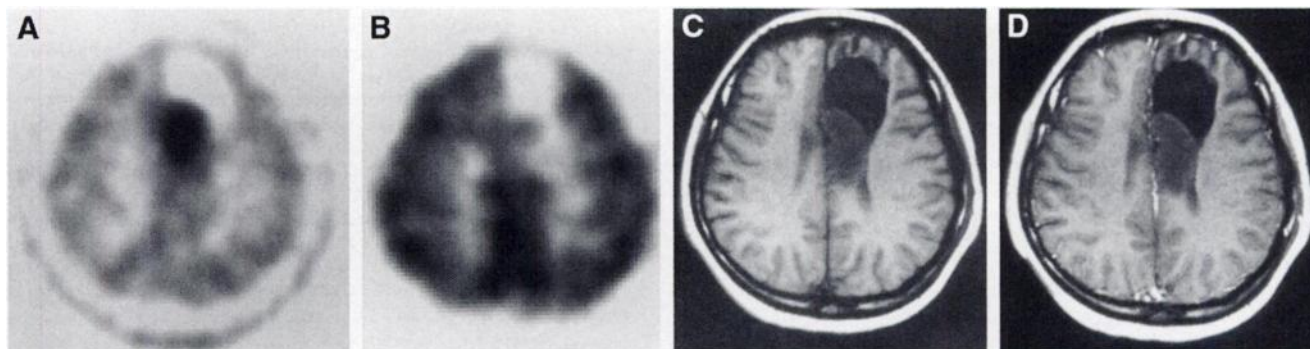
32-y-old woman with recurrent astrocytic tumor grade II (patient 6). (A) FMT PET image obtained at 30 min postinjection demonstrates higher tumor uptake with SUV of 2.5, whereas (B) FDG PET image obtained at 50 min postinjection shows partial tumor uptake. T1-weighted MR images obtained without (C) and with (D) contrast media reveal low-intensity mass with minimal contrast enhancement. Comparing surgical findings, tumor extent demonstrated on FMT PET image was more accurate than that on FDG PET image.
